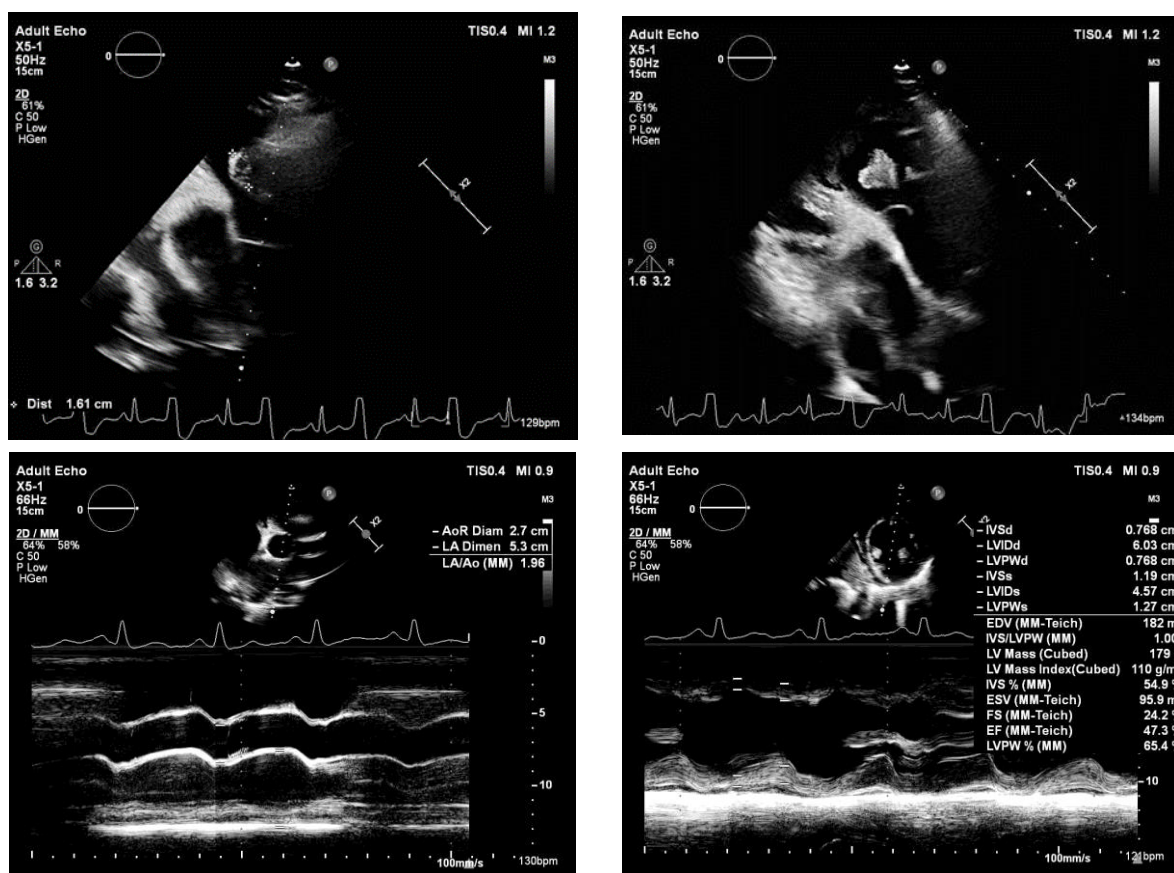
Transthoracic echocardiogram showing large vegetation 16×10 mm at the pulmonary valve area with pulmonic valve regurgitation.
